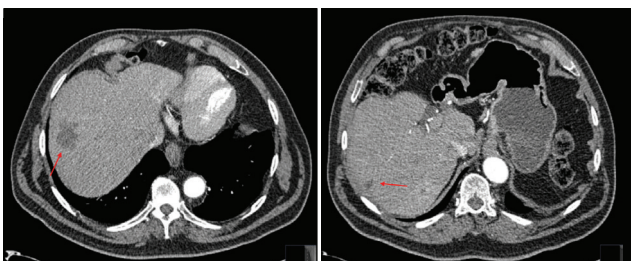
CT showing complete response in both lesions, with no arterial enhancement and significant reduction in size. No evidence of nontarget embolization is noted.
